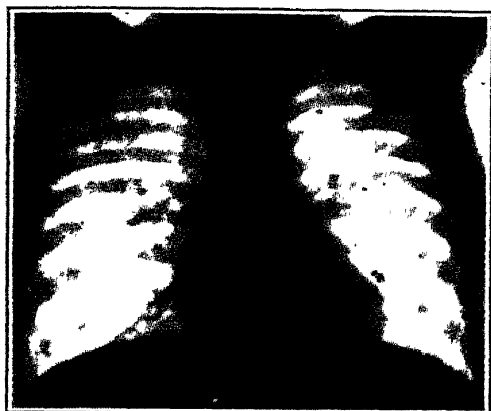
X-ray appearance April 21, 1933, at 10 years of age. (Boyd: J. A. M. A.)
